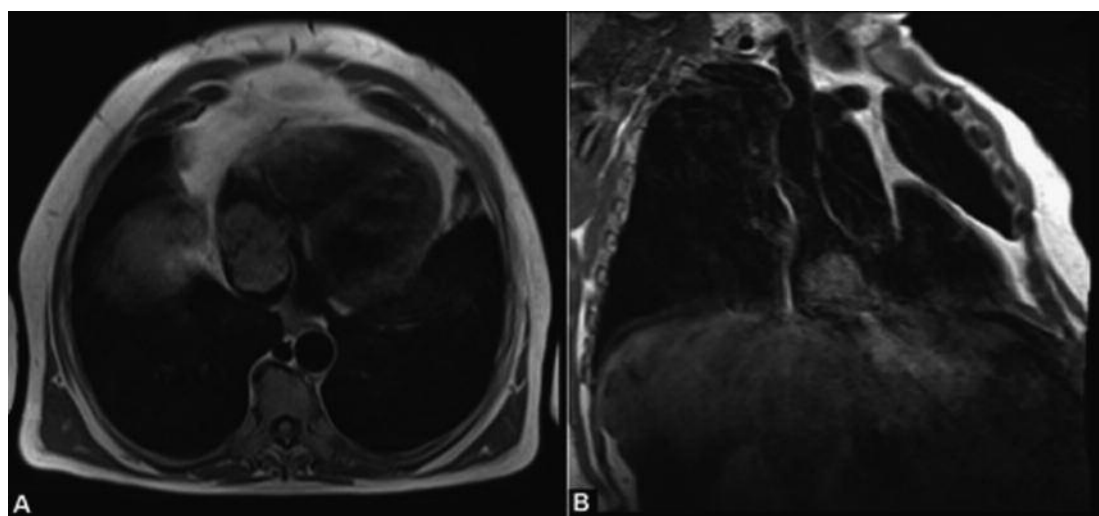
Cardiac Magnetic Resonance Imaging (MRI). A, Axial Scan. B, Coronal Scan.
